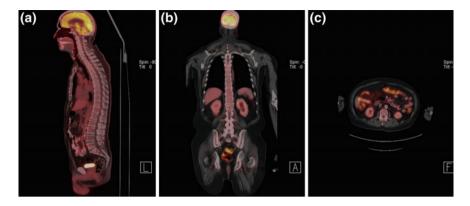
Example of PET/CT images obtained extending from the head to the mid-thighs. Fused CT and PET images in a sagittal, b coronal, and c axial projections. CT portion of the scan is in grayscale, with color over-projection of physiologic (PET) activity. Areas of *light yellow* to *orange* represent areas of increased radiotracer uptake, and areas of *red*, lower uptake. Note that there is a normal physiologic distribution of radiotracer, with increased uptake in the brain, and increased activity also seen in the bowel and bladder, not to be mistaken for pathologic uptake
